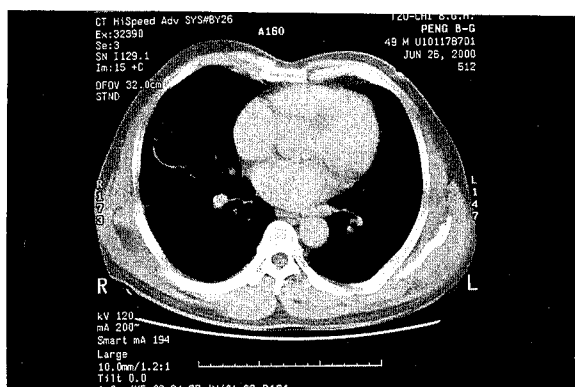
The CT scan demonstrates a thin-walled cystic lesion with irregular lining in the right middle lobe.
